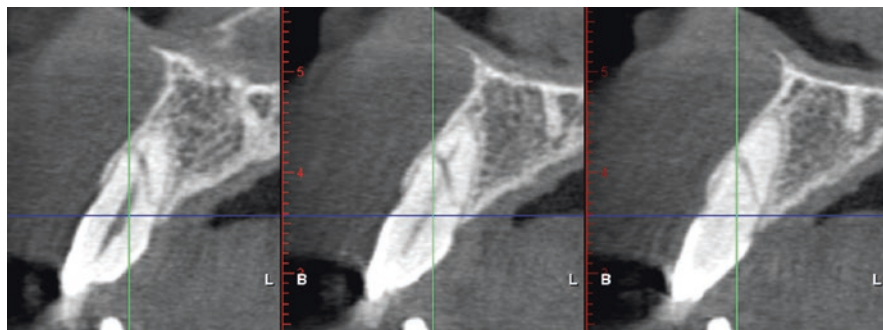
This is a cropped image of a small-field-of-view cone beam computed tomography of the right-hand-side maxillary permanent central incisor, which had been hurt in a bicycle accident 2 months prior to this exposure. Since the tooth was slightly mobile and the periapical radiograph (not included) was inconclusive the CBCT was taken and revealed an oblique fracture line from cervico-palatal to apico-buccal. Since there were no complaints from the patient it was decided to leave the tooth as it was
